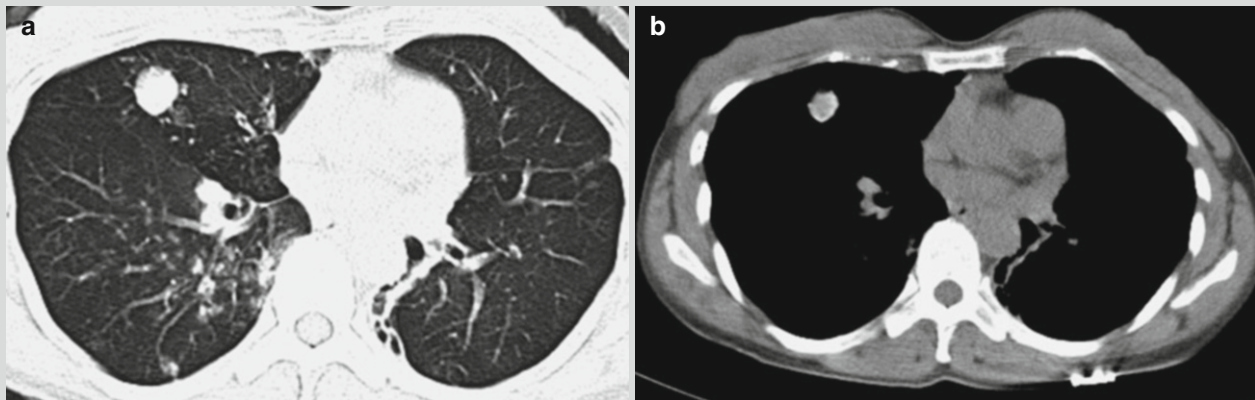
Pulmonary tuberculoma, infiltrative pulmonary TB. (a, b) CT scanning demonstrates spherical lesion at the right middle lung lobe, with marginal irregular calcification and well-defined
